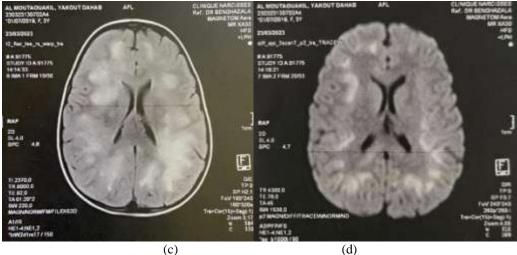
Brain MRI image showing areas of hyperintensity involving subcortical white matter of both cerebral hemispheres, and pedunculus cerebellaris Medius bilaterally in Axial T1 (a), Sagittal T2 (b), Axial T2-FLAIR (c), and Axial DWI (diffusion-weighted imaging).
